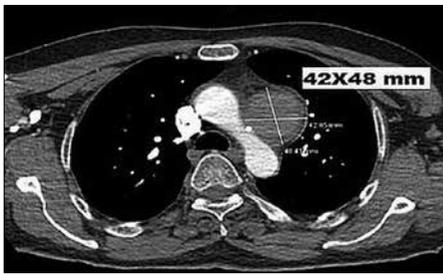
CT scans of intramural hematoma located in the arcus aorta
